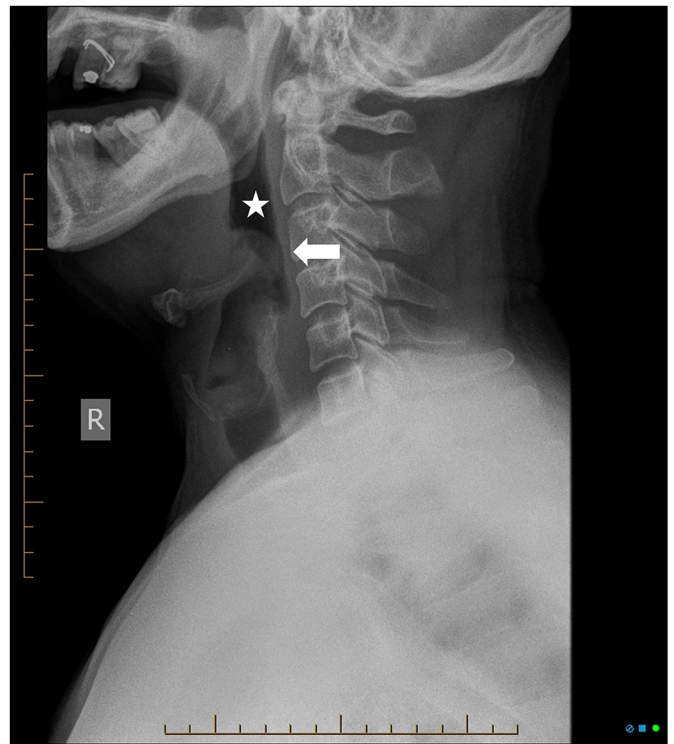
Lateral radiograph demonstrating the thumbprint sign (white arrow) and vallecula sign (white star) of epiglottitis. Case courtesy of Dr. Eric Brecher, [Radiopaedia.org](https://radiopaedia.org), rID: 41935.
